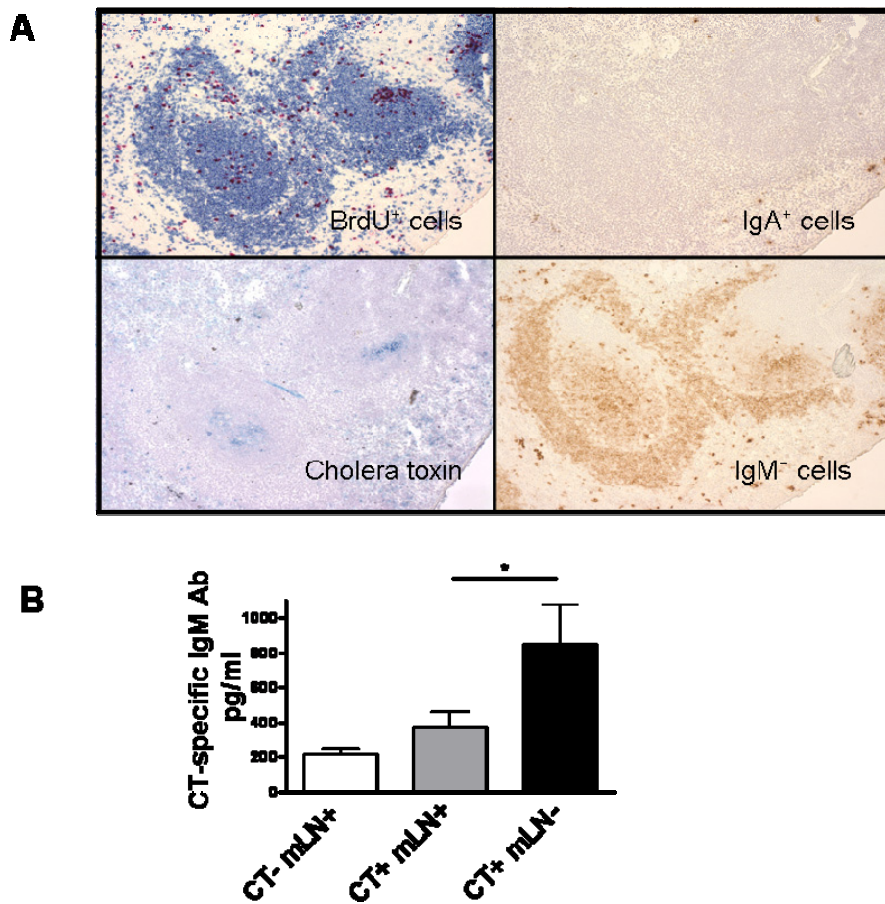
After CT treatment there are CT bearing germinal centres that induce IgM⁺ cells but no IgA⁺ cells
